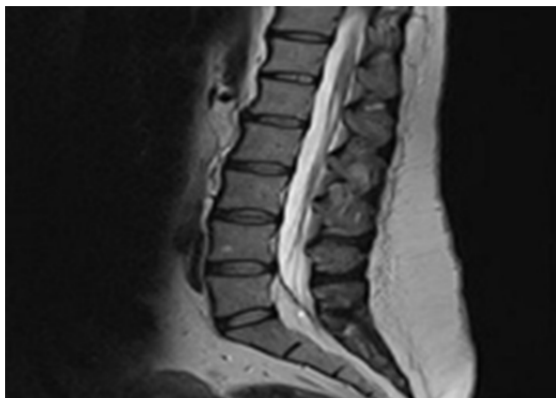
Sagittal T2 weighted MRI shows epidural lipomatosis with compression of the thecal sac in the L5/S1 region
